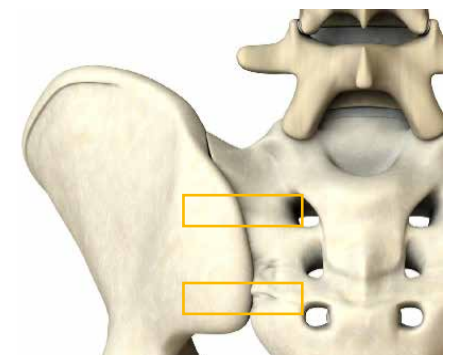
Sacroiliac joint in a transverse sonogram: joint space and indicated direction for infiltration → at the lower pole. Image 1 left and central, image 2 right (position of the probe indicated by the boxes); OI = ilium, OS = sacrum
